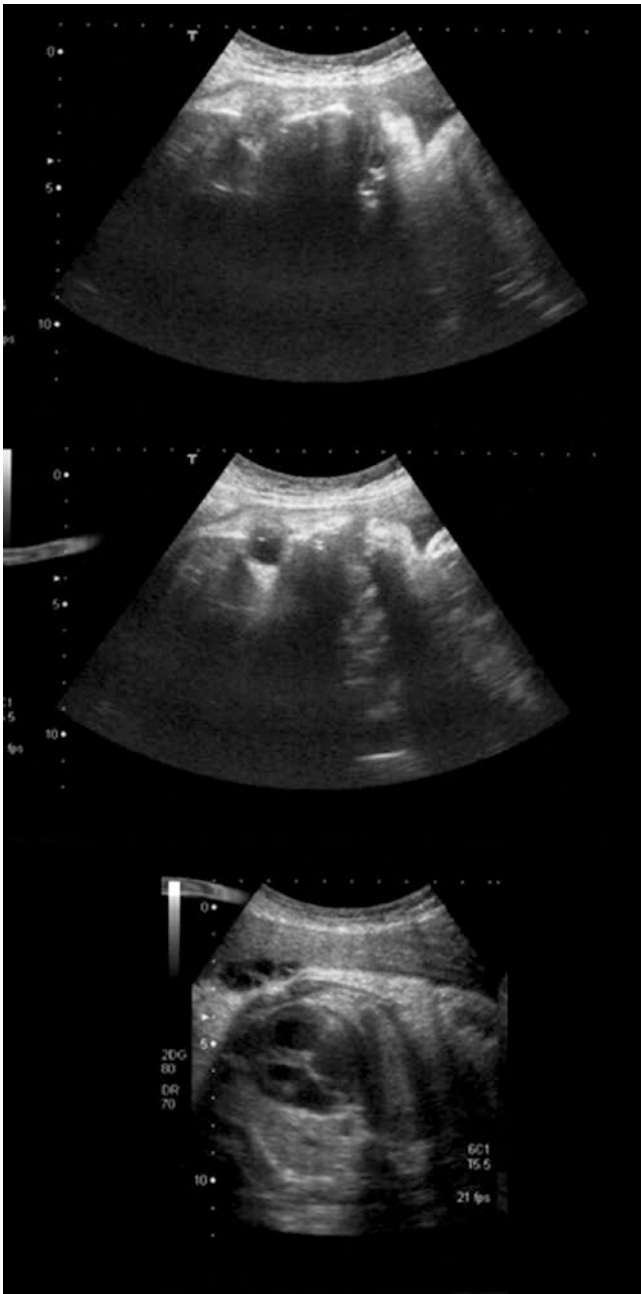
Lateral asynclitism and persistent occiput posterior position ultrasonographic signs: (1) asymmetric fetal profile (sagittal section), on the *top* of the image; (2) squint sign (transversal section), in the *medium*; (3) four chambers (transverse chest section), the *bottom* image; (4) posterior spine (transverse fetal chest section)
